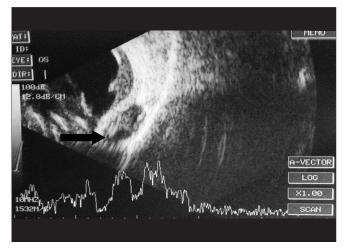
B-scan ultrasound of left eye showing posterior phacocele (black arrow)
